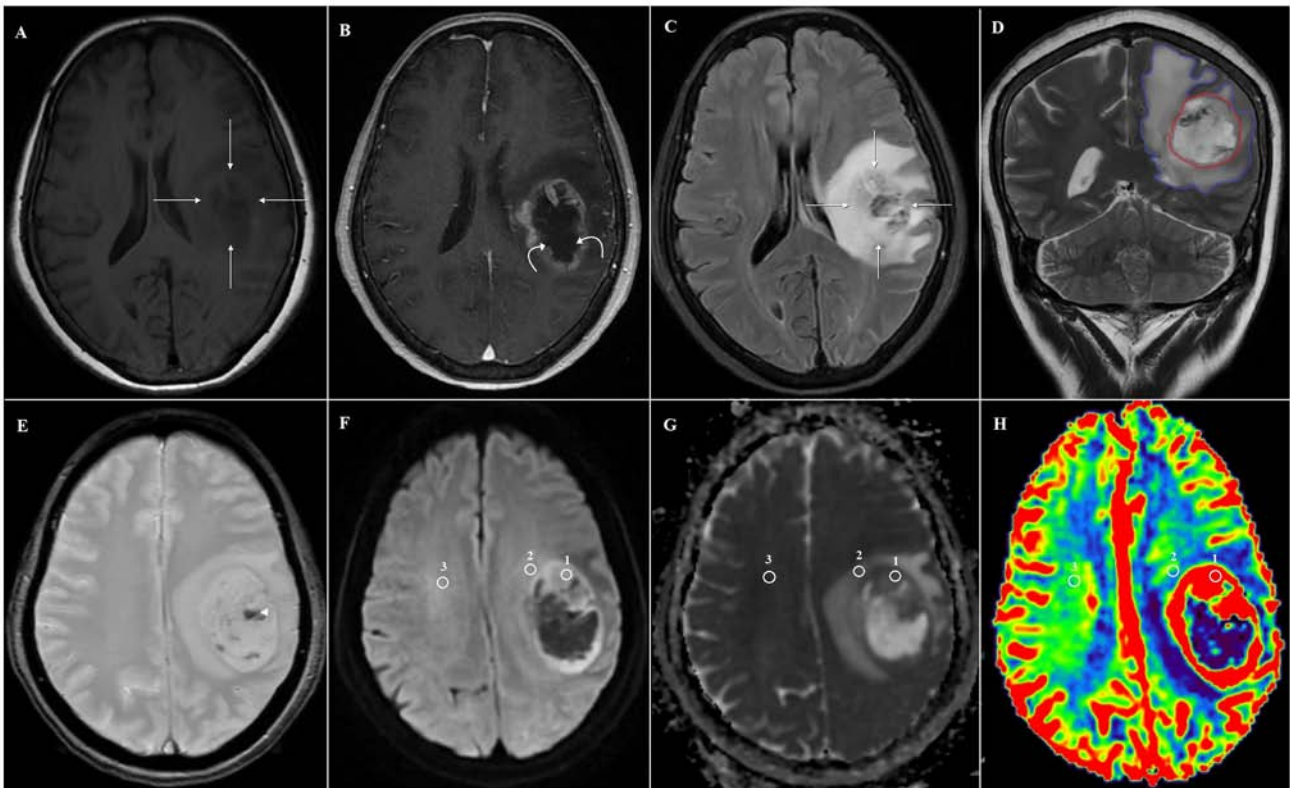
A 61-year-old woman with a GBM. (A) The MRI shows a mass (straight arrows) in the left frontal lobe. A comparison of (A) pre- and (B) post-contrast T1W images shows a heterogeneously enhanced tumor with central necrosis (curved arrows). (C) Axial FLAIR image shows peritumoral edema and infiltration. (D) The coronal T2W image with two manually drawn polygonal lines that include the entire peritumoral brain edema (blue line) and tumor (red line); the edema volume is ~equal to the tumor volume. (E) Hemorrhagic lesions (arrowhead) appear markedly hypointense on a conventional T2\* GE image. (F) Axial DWI and the corresponding (G) ADC map show a diffusion-restricted lesion within the enhanced tumor. (H) The color-coded CBV map shows higher vascularity in the normal white matter; three ROIs (circles) were placed in the solid tumor component (ROI 1), peritumoral region (ROI 2), and abnormal white matter (ROI 3). The minimum ADC was  $0.84 \times 10^{-3} \text{ mm}^2/\text{s}$  in the solid tumor (ADC<sub>t</sub>),  $1.14 \times 10^{-3} \text{ mm}^2/\text{s}$  in the peritumoral edema (ADC<sub>e</sub>), and  $0.62 \times 10^{-3} \text{ mm}^2/\text{s}$  in the normal white matter (ADC<sub>n</sub>). The rCBV value was 7.62 in the solid tumor (rCBV<sub>t</sub>), 1.61 in the peritumoral edema (rCBV<sub>e</sub>), and 1.77 in the normal white matter (rCBV<sub>n</sub>). GBM, glioblastoma; MRI, magnetic resonance imaging; T1W, contrast-enhanced T1-weighted; FLAIR, fluid-attenuated inversion recovery; ADC, apparent diffusion coefficient; CBV, cerebral blood volume; ROI, circular regions of interest; ADC<sub>t</sub>, solid tumor ADC value; ADC<sub>e</sub>, peritumoral edema; ADC<sub>n</sub>, normal white matter; rCBV, relative cerebral blood volume; rCBV<sub>n</sub>, normal white matter rCBV value.
